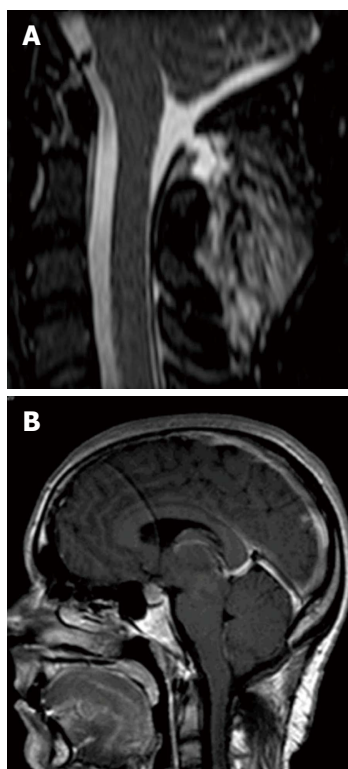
Magnetic resonance imaging signs of intracranial hypotension syndrome nine years after the craniectomy. A: 7 mm × 2.5 mm dural defect with an extradural collection at the dorsal soft tissues of the cervical spine; B: Less prominent engorgement of the dural venous sinuses, further enlargement of the pituitary gland and download displacement or sagging of the brain with effacement of the perichiasmatic cisterns and the prepontine cistern.
